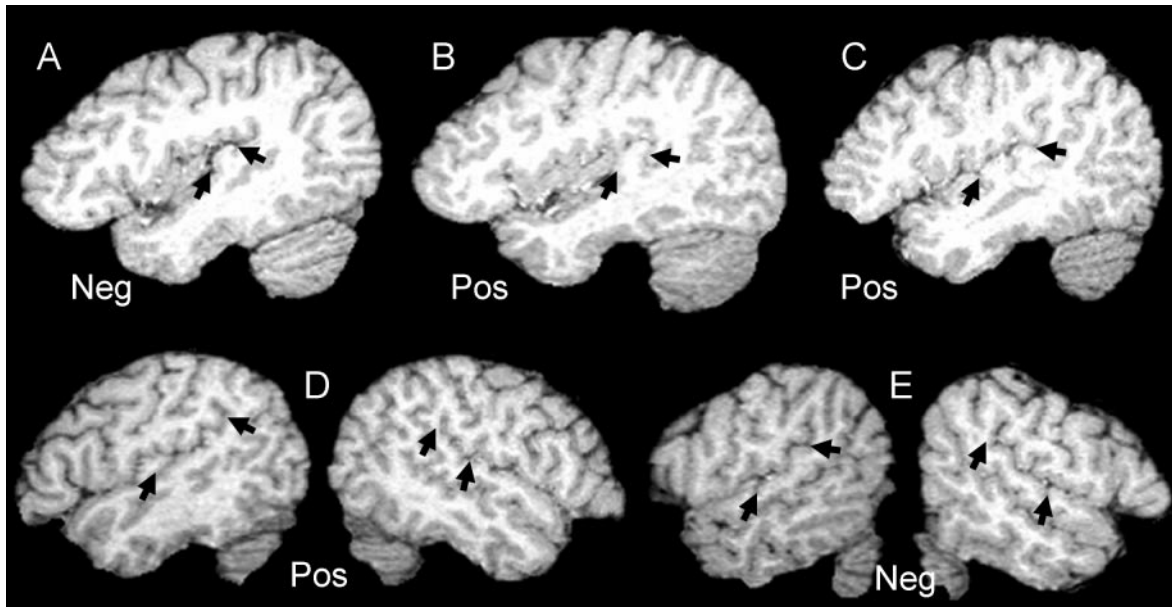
MRI images of Heschl's gyrus (*top*) and the planum temporale (*bottom*). (A) Small Heschl's gyrus typical in brains with negative anatomical risk indices (Neg); (B) Large Heschl's gyrus typical of brains with positive anatomical risk indices (Pos). (C) Duplicated Heschl's gyri typical of brains with positive anatomical risk indices. (D) Typical leftward asymmetry of the planum temporale. (E) A large planum temporale in the right hemisphere.
